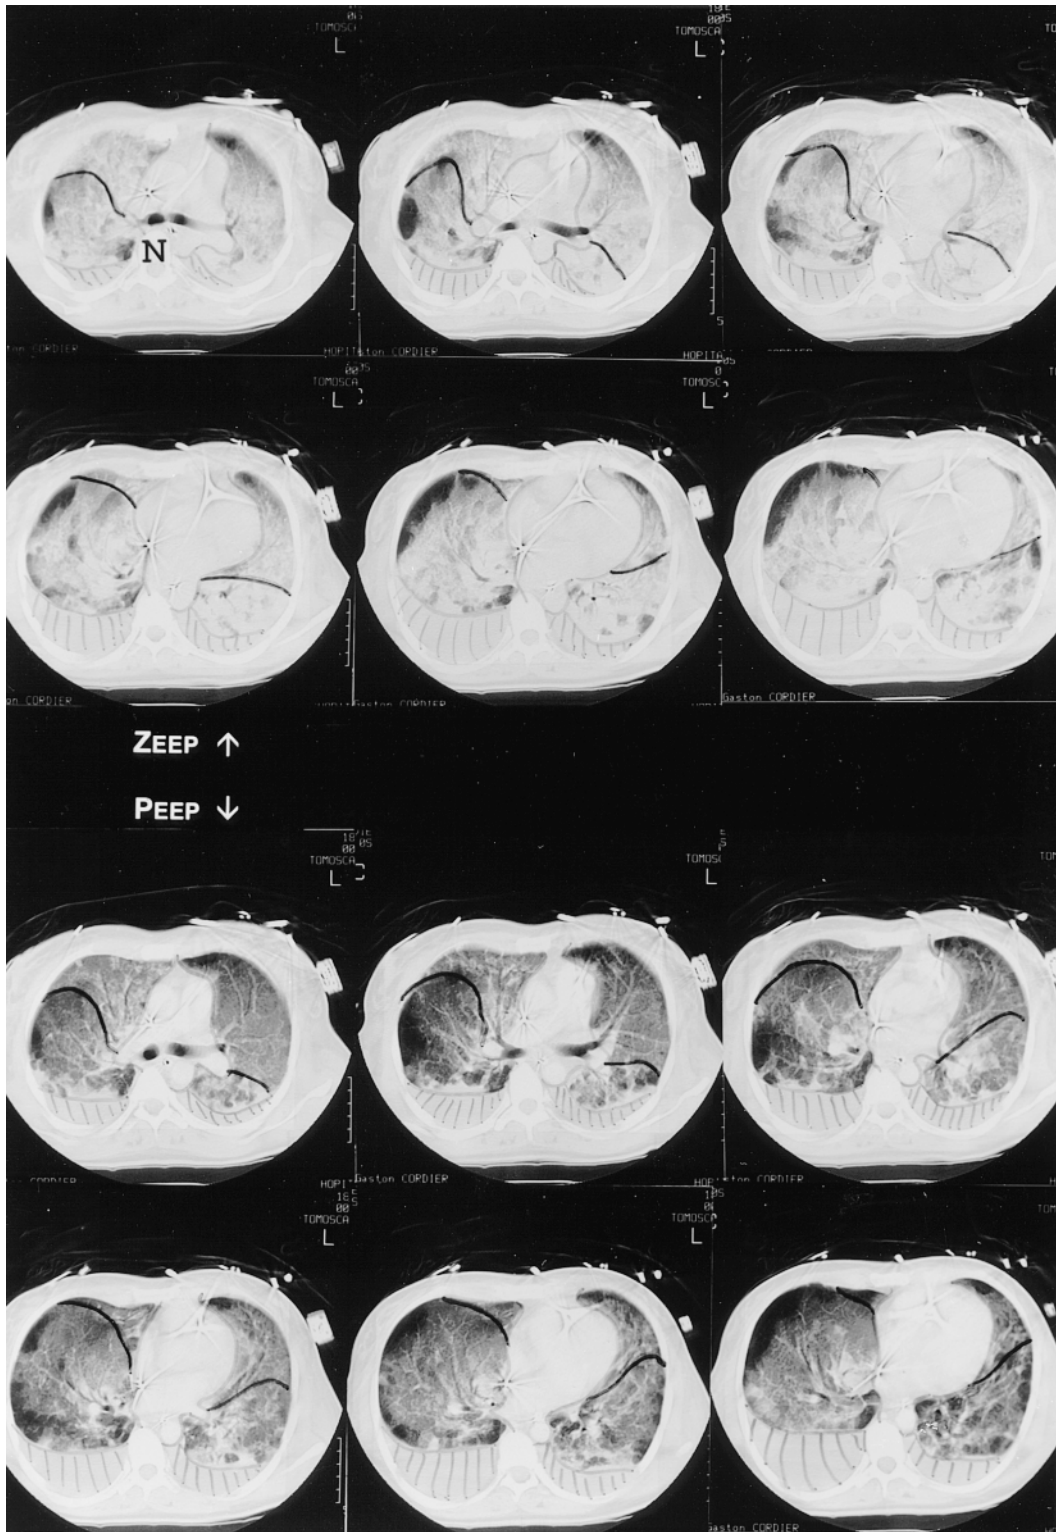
CT scan of a recruiter patient (Patient 21) showing no reduction in the volume of lower lobes and a marked alveolar recruitment with PEEP. The *black line* represents the position of the major fissura. The *hatched areas* represent the pleural fluid. The characteristics of this patient are shown in Tables 1 and 2.
